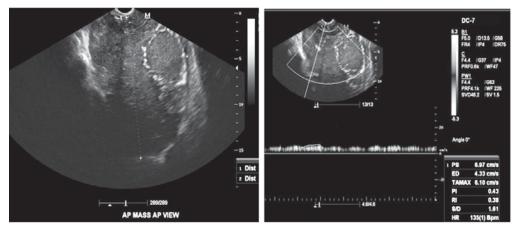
Abdominopelvic mass and Color Flow mapping of the mass. Occupying the abdominopelvic cavity is an irregular, solid movable mass measuring 15.5cm x 13.5cm x 12.2cm. Color flow mapping of the abdominopelvic mass shows moderate vascularity which on Doppler interrogation revealed low resistance indices (PI=0.43, RI=0.38).
